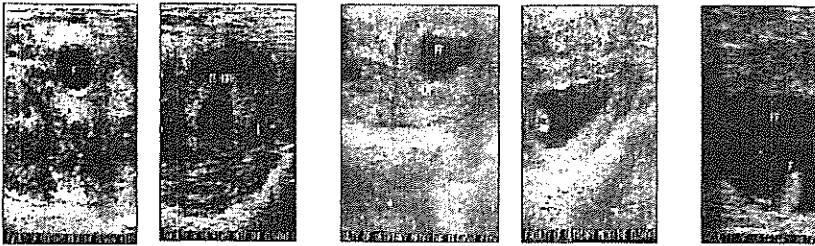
Ultrasonograms of inactive ovaries of heifers. (Notice that ovaries are small and elliptical)
